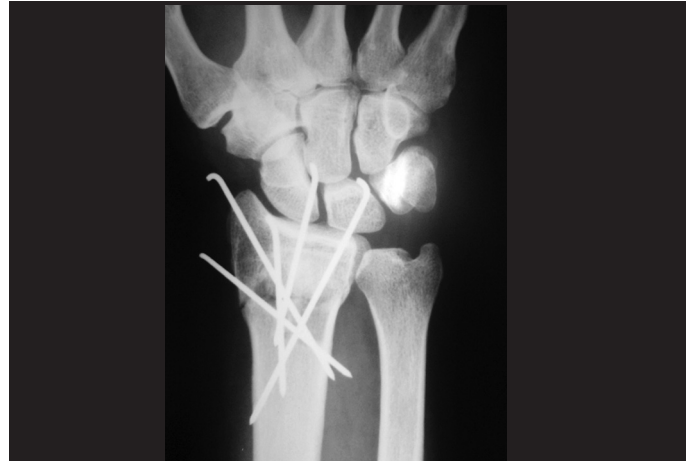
Radiograph on wrist showing the immediate postoperative result in posteroanterior view, after fixation of the fracture of the distal radius using Kirschner wires, with correction of the radial angulation and restoration of the radial height.
